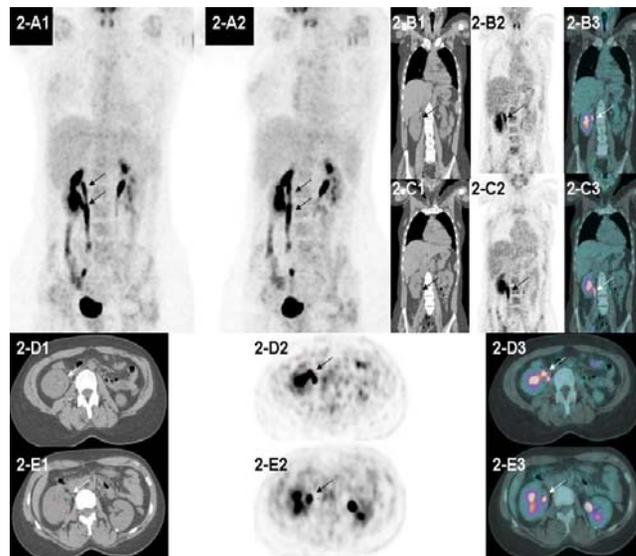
Anterior view (2-A1) and left oblique anterior view at 30° (2-A2) of maximum intensity projection show double left kidney collecting system (arrows). Axial PET (2-D2), CT (2-D1), fused (2-D3), coronal CT (2-C1), PET (2-C2) and fused (2-C3) images show lower pelvis (arrows); axial PET (2-E2), CT (2-E1), fused (2-E3), coronal CT (2-B1), PET (2-B2) and fused (2-B3) images show upper pelvis (arrows).
